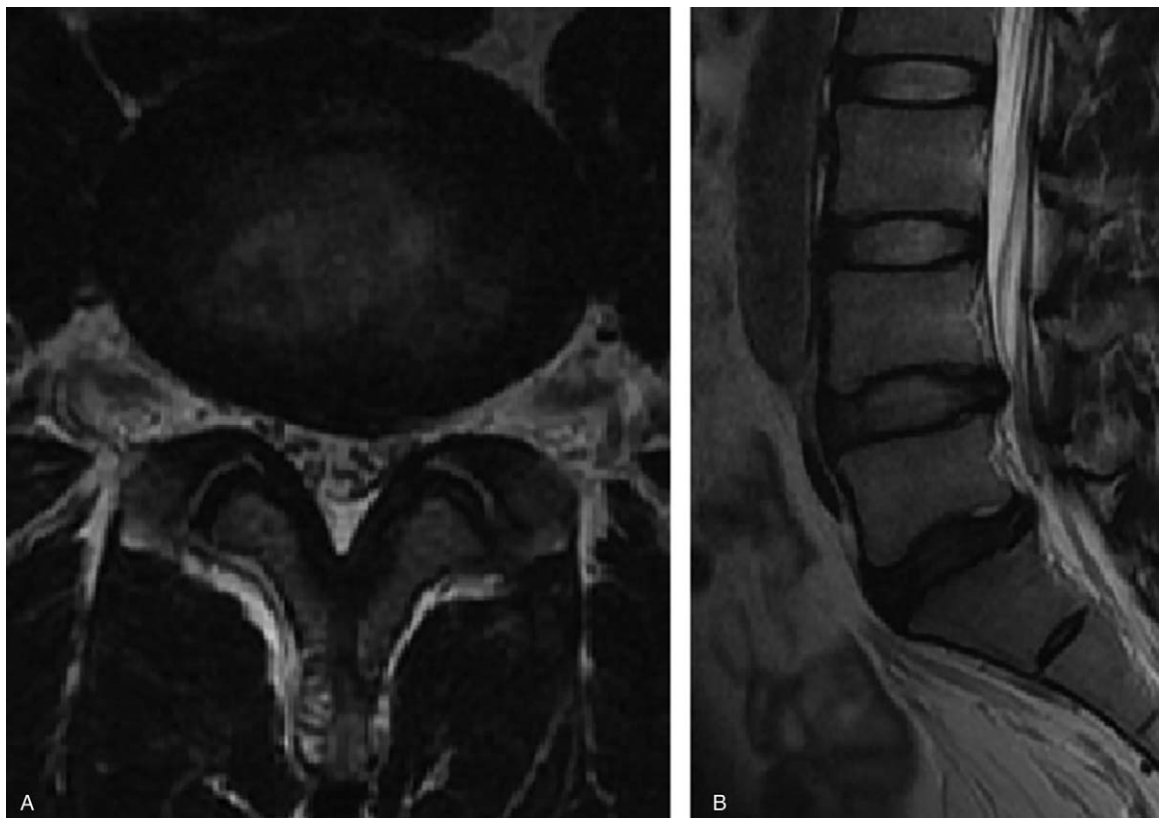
T2-weighted magnetic resonance imaging of patient L. A: Transverse plane image of L4–5 level. B: Right sagittal image of lumbar spine.
